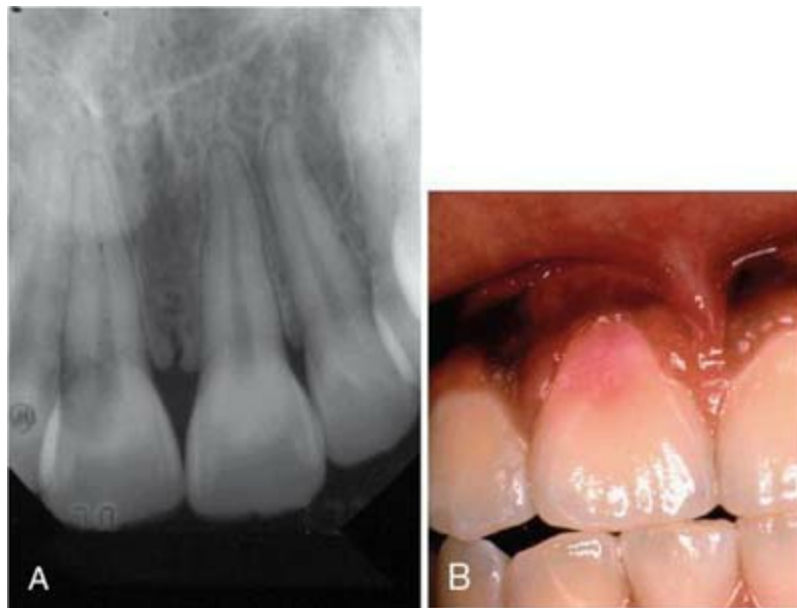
Pink spot of invasive cervical root resorption. A, Radiographic appearance. B, Clinical appearance.
